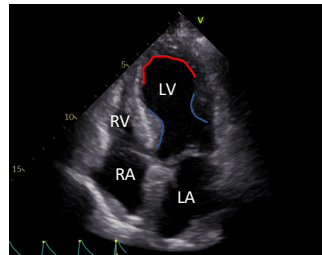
Echocardiogram with newly reduced ejection fraction (31%), apical segmental hypokinesis, and basilar hyperkinesis.
